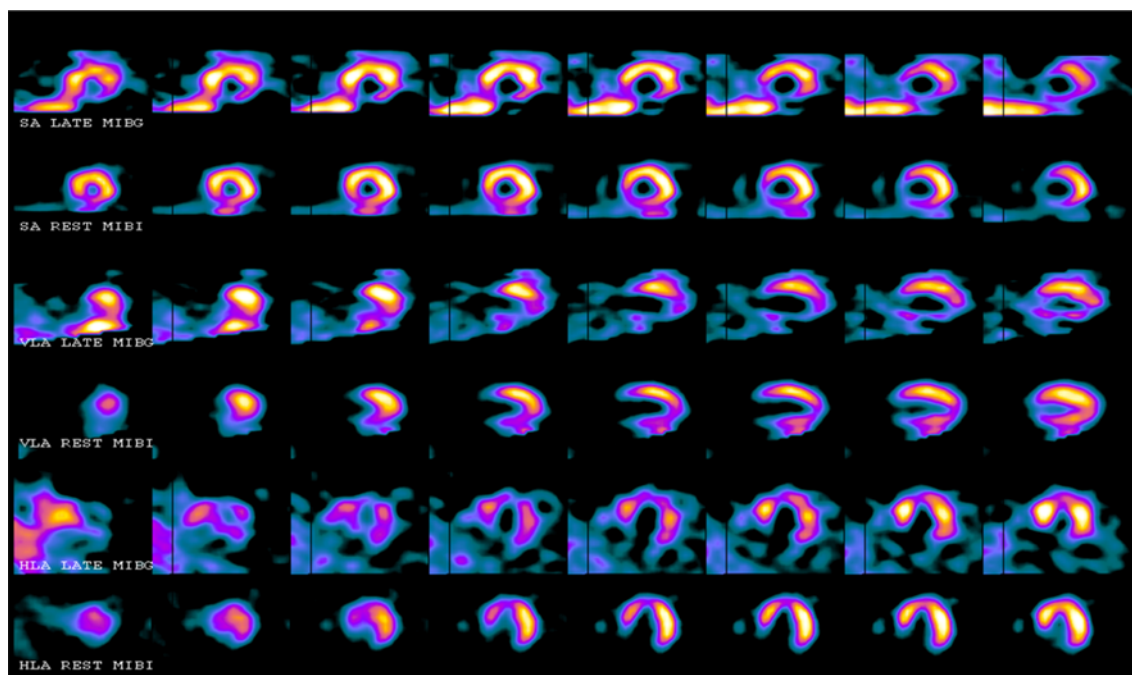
^{123}I -mIBG and $^{99\text{m}}\text{Tc}$ -sestamibi SPECT images of a patient who had received numerous appropriate ICD shocks. There are neuronal/perfusion mismatching defects involving the inferior, inferolateral, and apical walls; there is a matched defect in the anterior wall. HLA, Horizontal long axis; ICD, implantable cardioverter defibrillator; MIBG, metaiodobenzylguanidine (^{123}I -mIBG); MIBI, $^{99\text{m}}\text{Tc}$ -sestamibi; SA, short axis. Reprinted from Ji and Travin²⁰ with kind permission from Springer Science and Business Media.
